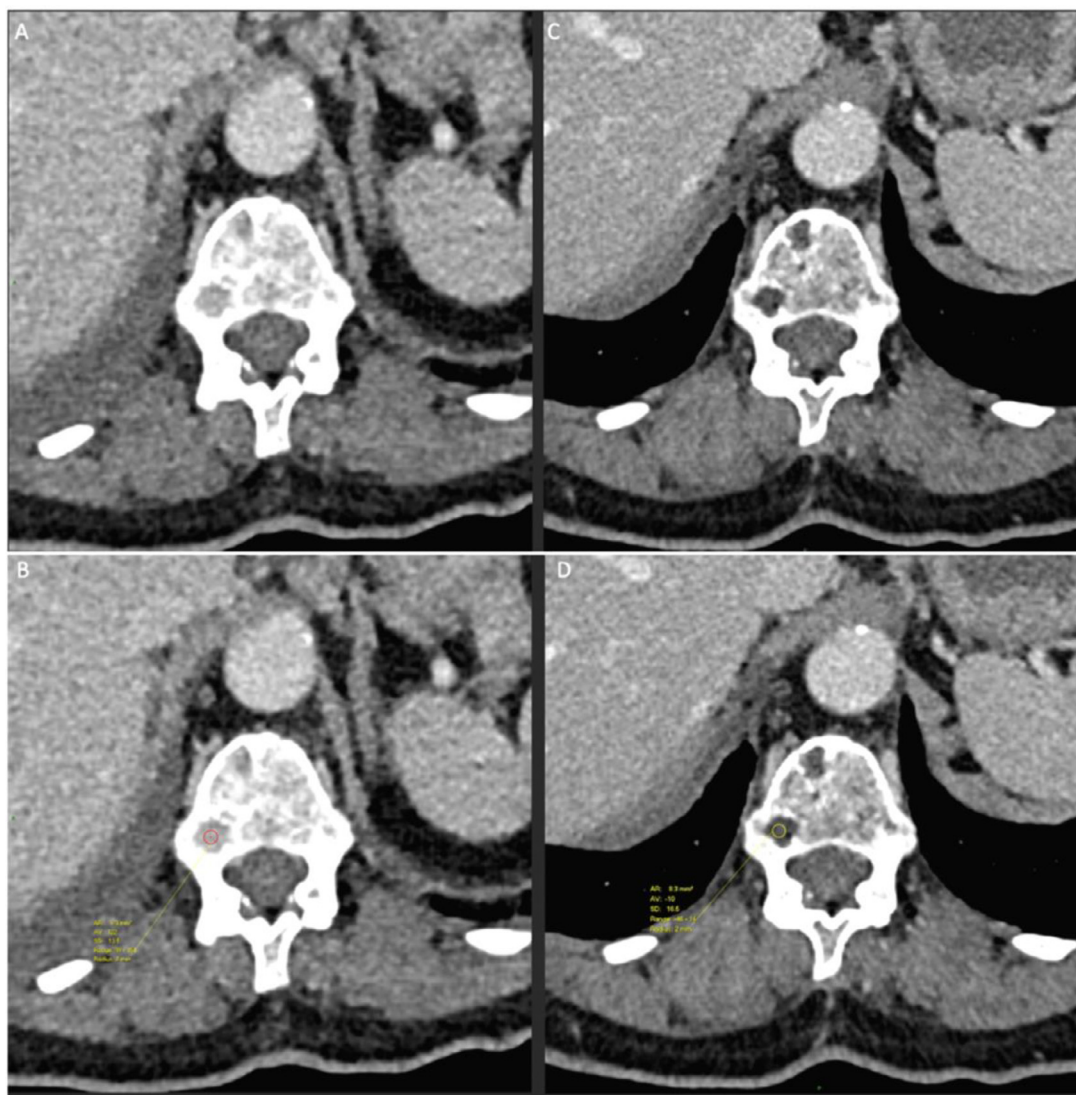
(A, B) Initial staging CT demonstrates 2 lytic bony lesions involving the L1 vertebral body with soft tissue component and mean CT attenuation threshold of 122 HU, appearances are consistent with lytic bone metastases. Images C and D show postsystemic treatment surveillance CT which shows the previous 2 lytic bony lesions involving the L1 vertebral body demonstrating complete fatty replacement (measured Hounsfield unit -10) in keeping with response to treatment.
